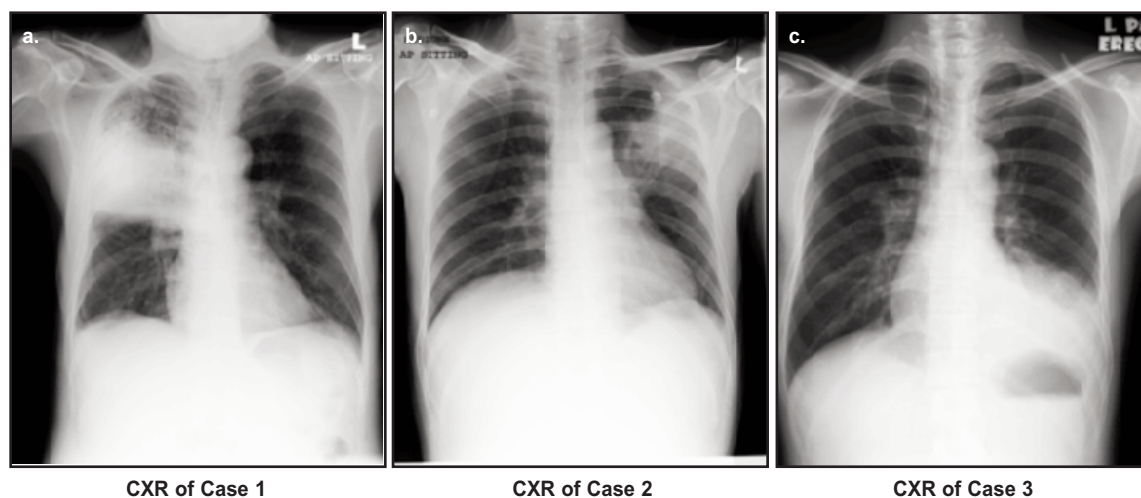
A, 1 B, 1 C: Chest X-Ray of Case 1, 2 and 3.
